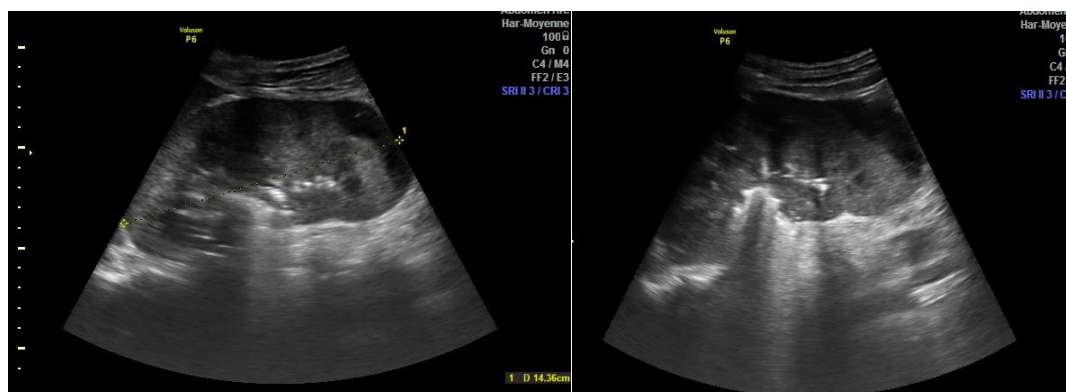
Kidney ultrasound showing nephromegaly with inferior polar abscess
